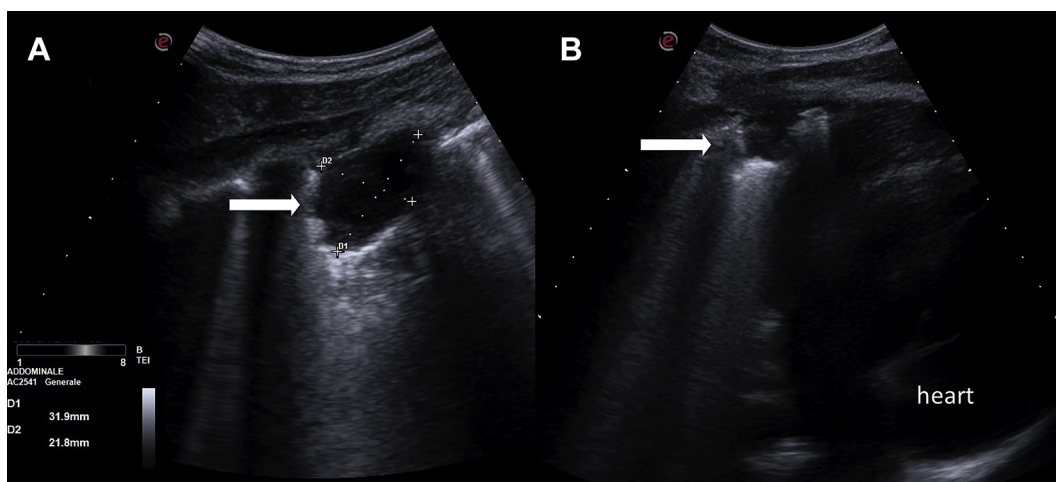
A, B, Two images of the same pulmonary consolidation, with different deep setting, in a 8-year-old child referred to the ED for acute chest pain and fever. The scan was performed by a convex probe in the region of pain indicated by the patient. Chest radiograph confirmed the diagnosis of pneumonia.
